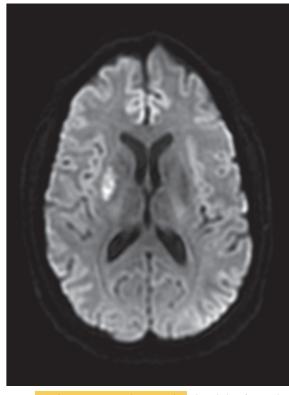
MRI showing an acute ischaemic stroke in the right lentiform nucleus
